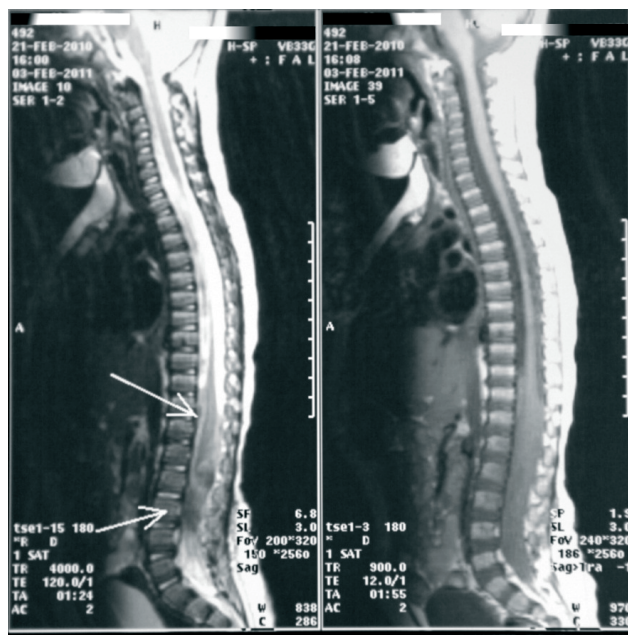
MRI of thoracolumbar spine.
